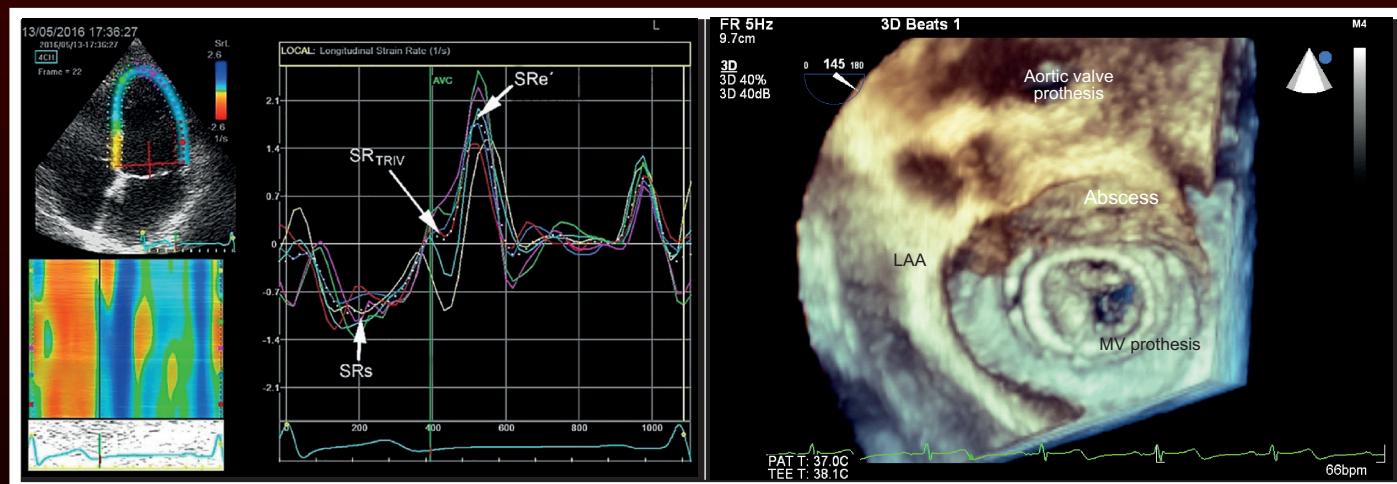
Determination of strain rate from the 4-apical chamber position. The image reveals the following components: systolic strain rate (SRs), strain rate during isovolumetric relaxation time (SRIVRT), early diastolic strain rate (SRe'). AVC: aortic valve closure. Pág. 112; Figura 4 – Three-dimensional echocardiogram images showing aortic periprosthetic neocavity extending to the mitroaortic junction. Pág. 136
